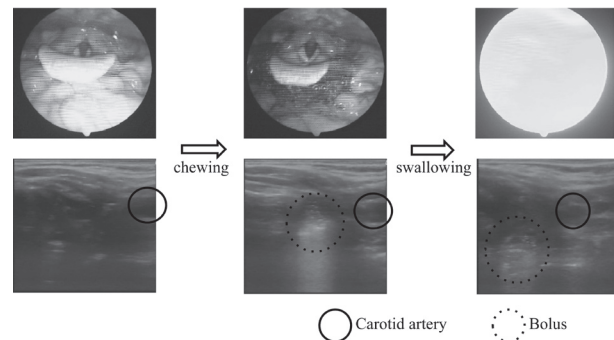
Ultrasound images around the pharynx when the ultrasonic probe was positioned on the skin over the thyroid cartilage.
